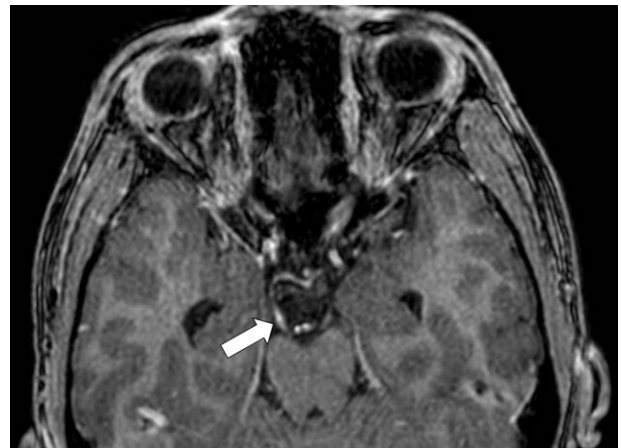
MRI. Axial post-gadolinium fat saturated T1-weighted MRI demonstrating enhancement of right oculomotor nerve (white arrow). Image quality is limited due to motion artifacts.
